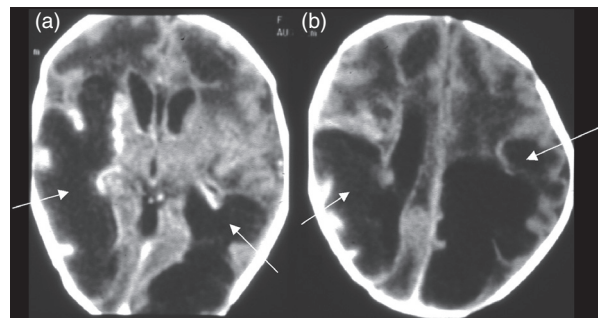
Citrobacter* meningitis: (a,b) CT with contrast-enhancing abscesses (arrows), ventriculitis, and hydrocephalus.
